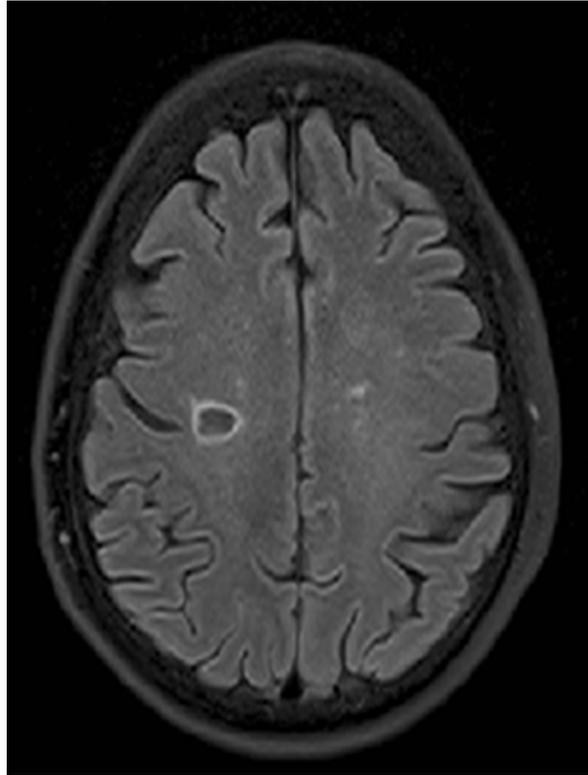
MRI FLAIR image showing a lacunar infarct in the right territory of the middle cerebral artery (patient 13).
